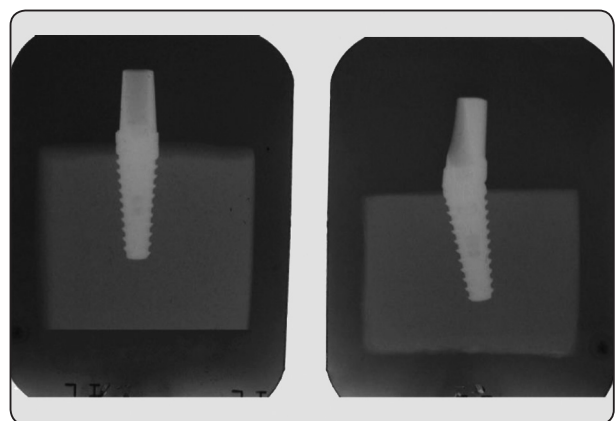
X-rays showing matching diameter straight (left) and angled (right) abutments.
